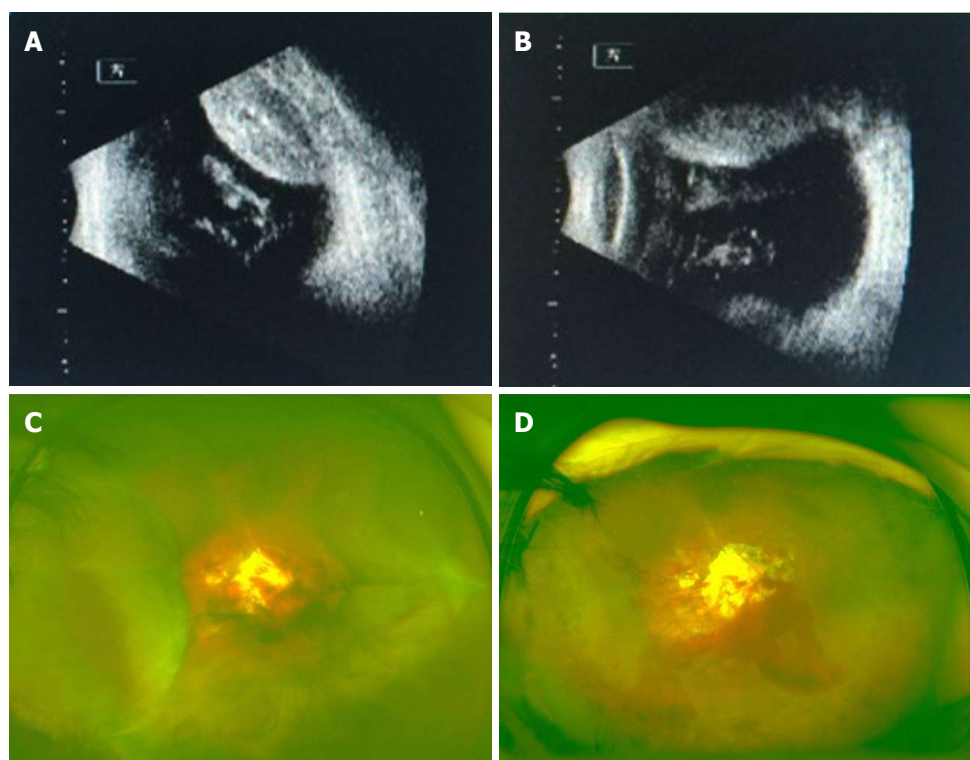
Clinical findings in patient 3. A, B: An ultrasound showed choroidal detachment; C: A fundus examination revealed prominent choroidal detachment in four quadrants; D: Complete drainage of the suprachoroidal hemorrhage and flat retina was observed after vitrectomy was finished.
